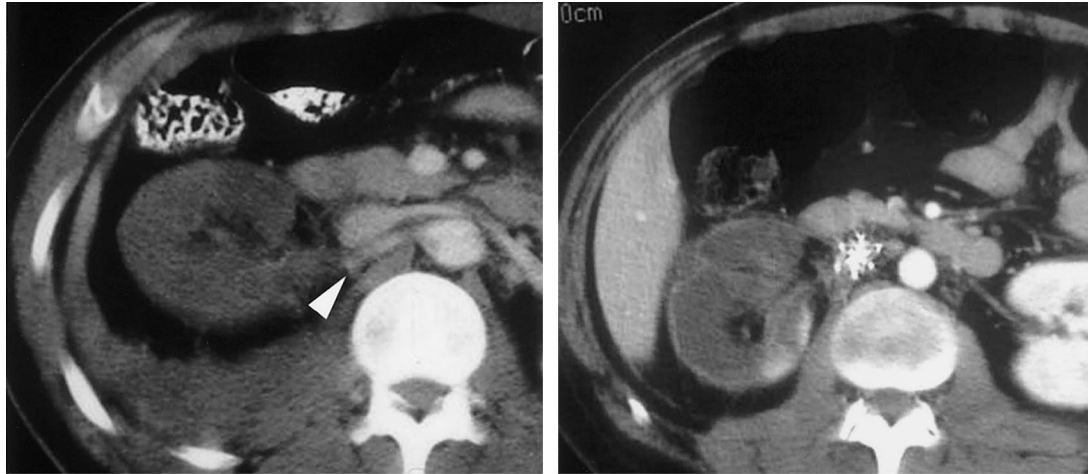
Rim sign of vascular compromise. (a) Enhanced CT scan of a motor vehicle accident victim demonstrates no perfusion in the majority of the right kidney. The right renal artery abruptly terminates; this is the arterial cut-off sign (arrowhead). (b) Repeat contrast-enhanced CT scan, obtained 72 hours after a, demonstrates a thin marginal rim of preserved subcapsular enhancement in the left kidney, typical of the rim sign of renovascular compromise. Vascular compromise in this case was caused by intimal injury and thrombosis of the main renal artery.
